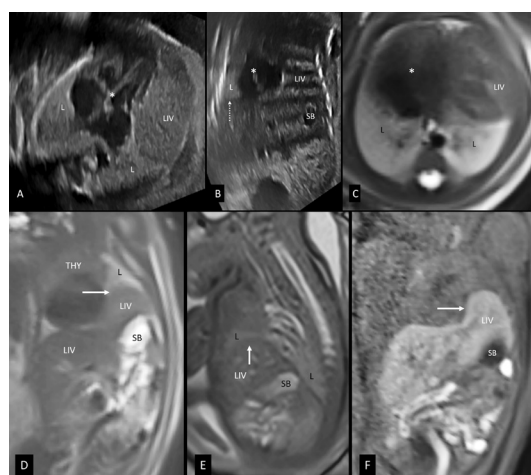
Prenatal ultrasound axial image (A) at the level of heart (*) reveals intrathoracic herniation of the liver with mediastinal shift to the right. Anterior coronal image (B) reveals intrathoracic herniation of the liver; stomach bubble appears intra-abdominal. There is mediastinal shift to the right. Right hemidiaphragm is visualised (dotted white arrow). Axial T2-weighted HASTE (Half-Fourier Acquisition Single-shot Turbo spin Echo imaging) image (C) of prenatal MRI shows intrathoracic liver and displacement of the heart (*) to the right side. Note the normal signal intensity of bilateral lungs. (D) Coronal T2-weighted HASTE (Half-Fourier Acquisition Single-shot Turbo spin Echo imaging) image shows a focal bulge in the left hemidiaphragm (arrow) with superior displacement of the left lobe of the liver. (E) Sagittal TRUFISP (True fast imaging with steady state precession) image shows complete T2 hypointense left hemidiaphragm with focal anterior bulge (arrow). (F) Coronal T1-weighted VIBE (Volumetric interpolated breath-hold examination) image clearly depicts the focal bulge in the intact left hemidiaphragm (arrow), confirming the diagnosis of focal eventration of the left hemidiaphragm. L, lungs; LIV, liver; SB, stomach bubble; THY, thymus.
